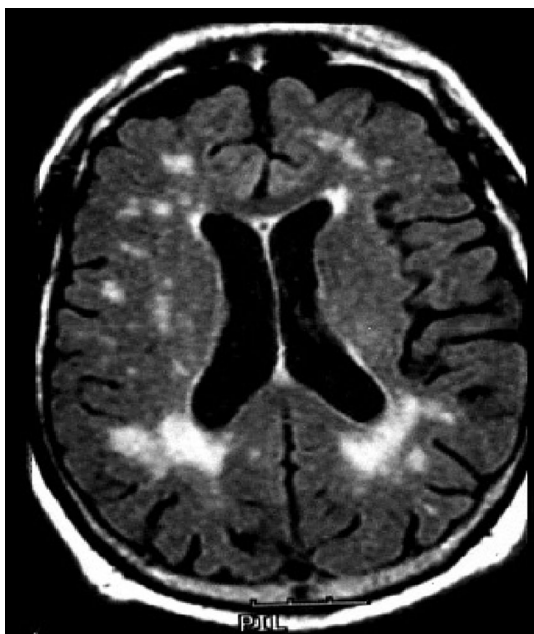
Axial plane of a FLAIR MRI sequence. The hyperintense areas in the parenchyma correspond to white matter lesions that appear as a result of microvascular alterations and ischemia
